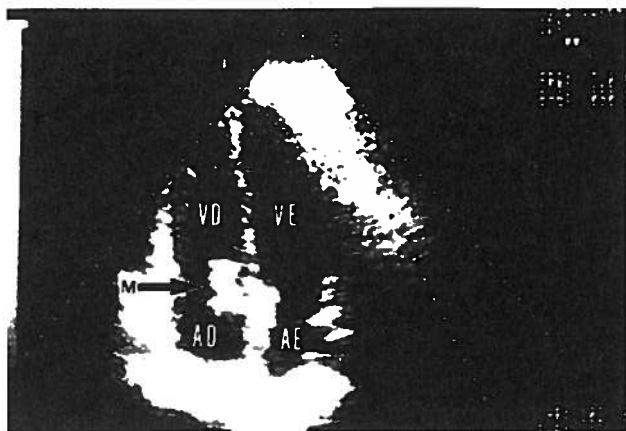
mode echocardiogram (4 chamber view): right atrial mass (M) adherent to the atrial septum. AD (right atrium), VD (right ventricle), VE (left ventricle).
